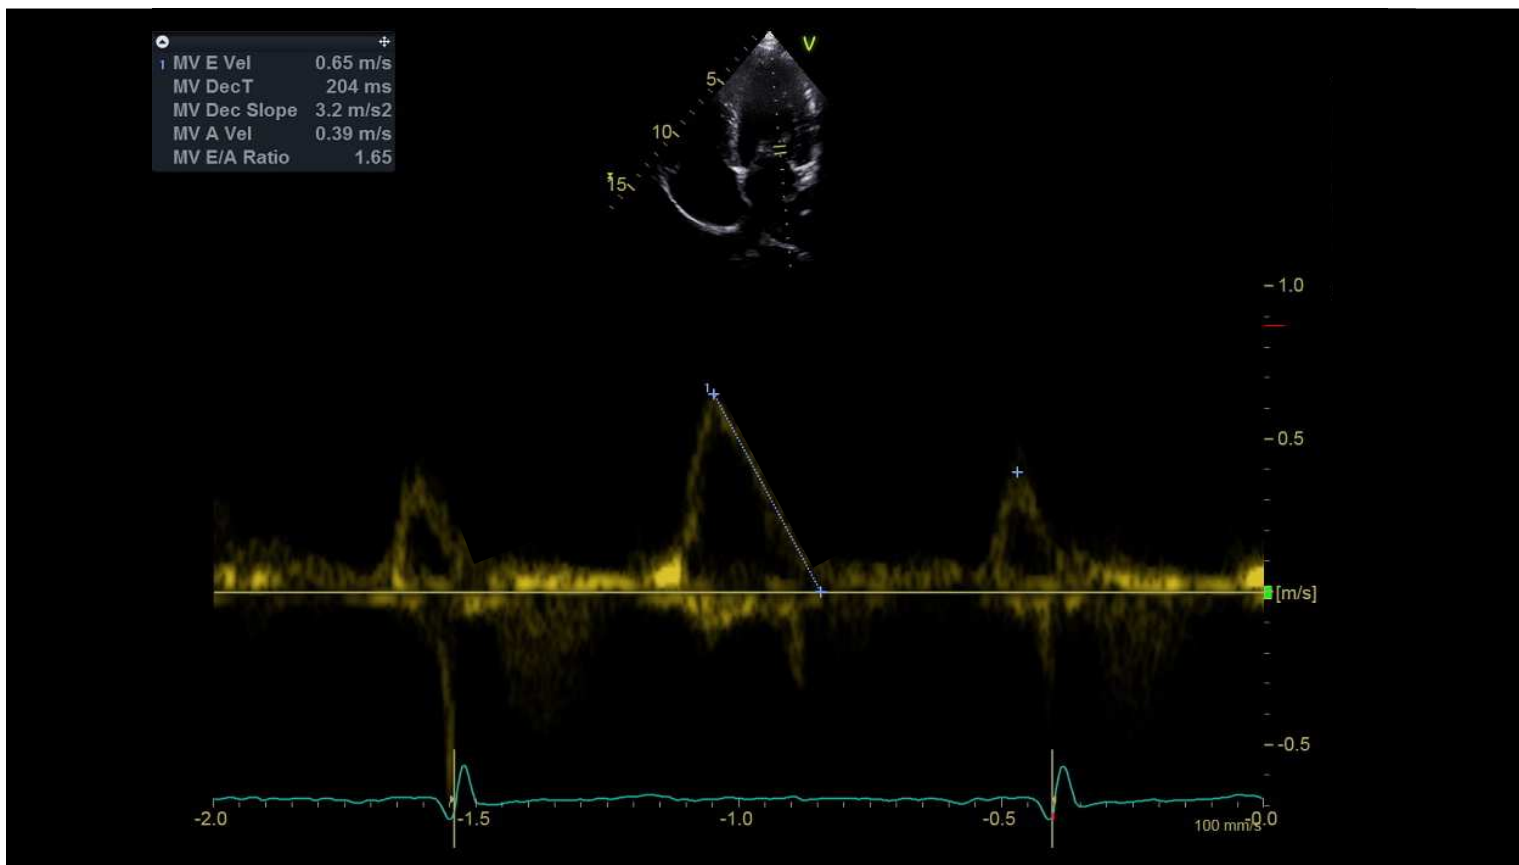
Pulsed wave Doppler trace of the LV blood flow through the mitral valve during diastolic filling.
